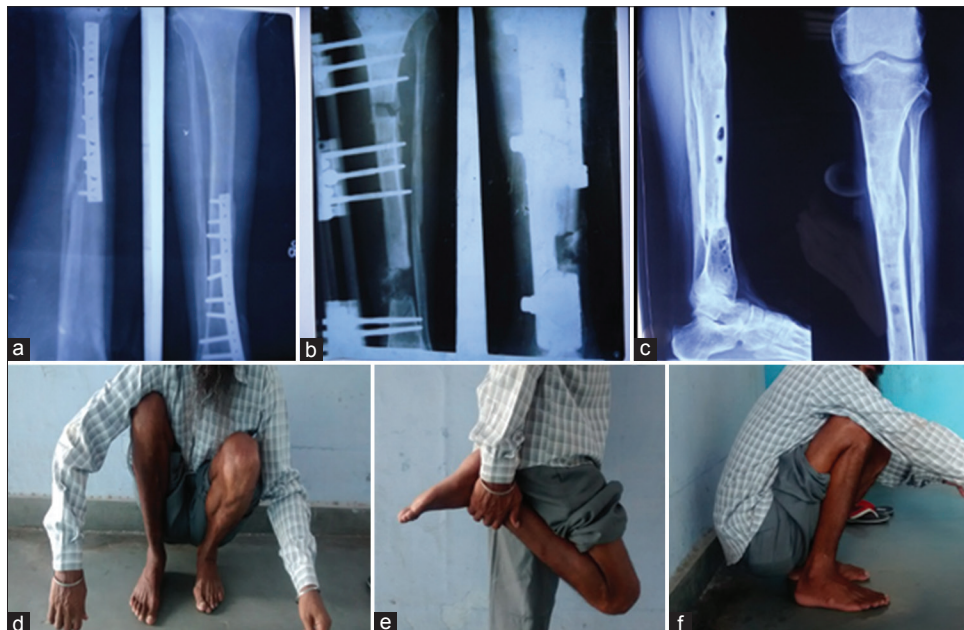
X-ray of implant *in situ* (a), X-ray of rail fixator *in situ* during distraction osteogenesis (b), X-ray showing union (c), after removal of rail fixator the patient is able to squat with good functional outcome (d), and showing range of motion at adjacent joints (e and f)
